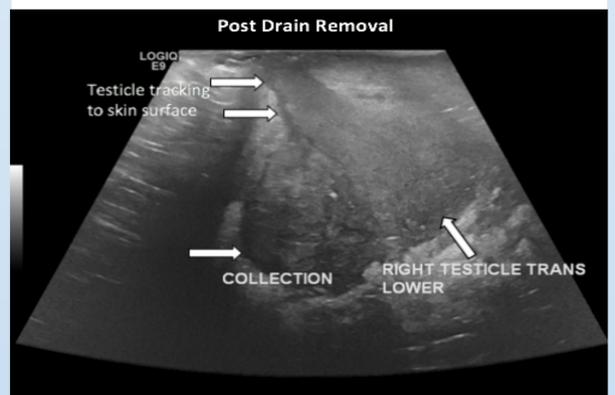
Transverse image of the inferior pole of the right testicle which appeared to track to the skin surface at the site of the prior drain. The discontinuity of the tunica albuginea which surrounds the testis is sonographically consistent with testicular rupture (Adlan and Freeman, 2014).
